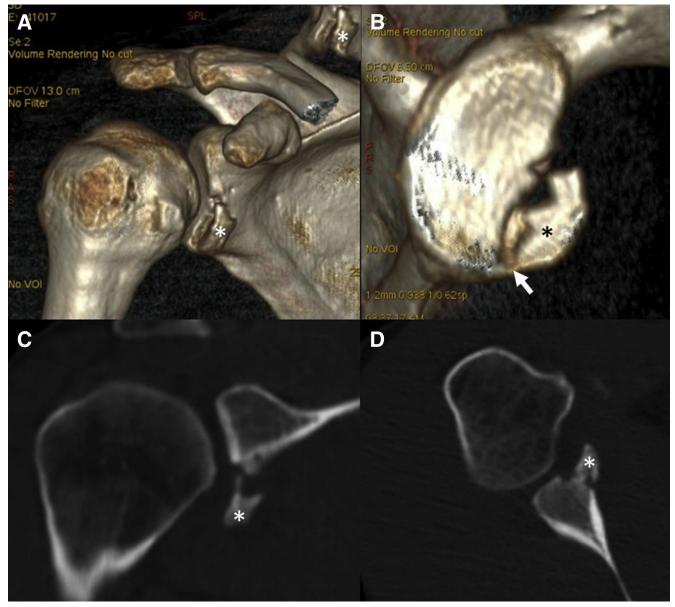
Computed tomography images of the right shoulder presented in the case. (A) 3-Dimensional (3D) reconstruction, frontal view. (B) 3D reconstruction, lateral view. (C) 2D coronal scan at the fracture site. (D) 2D transverse scan at the fracture site. Images show a medially dislocated bulky fragment (*), detached from the subequatorial anterior-inferior portion of the glenoid, with a smaller third fragment in between. Its most distal portion shows a minimal displacement (arrow in B), suggesting continuity with the capsular-labral complex.
